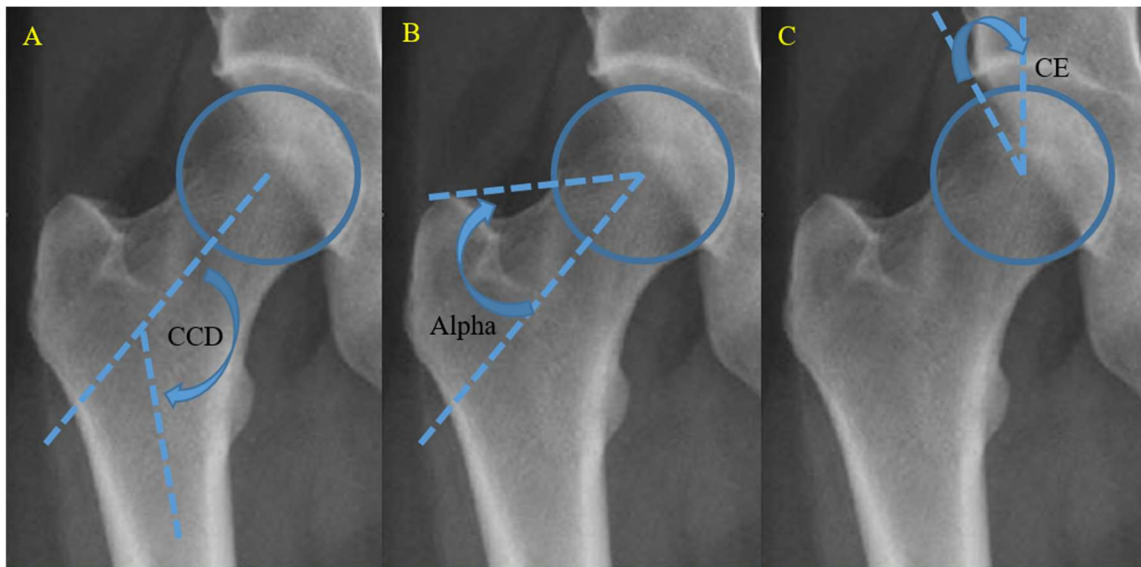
Radiographic measurements for femoral head shape abnormality. A, measurement of centrum collum disphyseal; B, measurement of alpha angle; C, measurement of centre edge angle. (figure source: Röling et al., 2020, under CC-BY-SA license).
